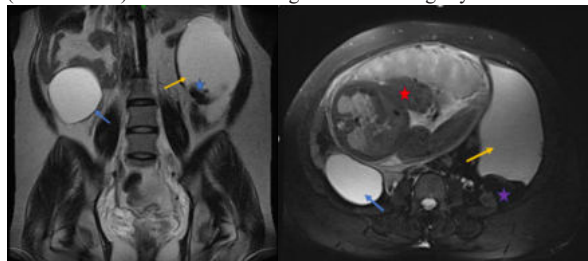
MR images (T2 weighted) Coronal (2:A) and axial sections (2:B) showing right adnexal cystic lesion (blue arrow); left adnexal large cyst (orange arrow) with papillary projections (blue star). A solid component (purple star) is seen along the postero-inferior wall of the lesion. The gravid uterus and fetus can be seen anteriorly (red star).
